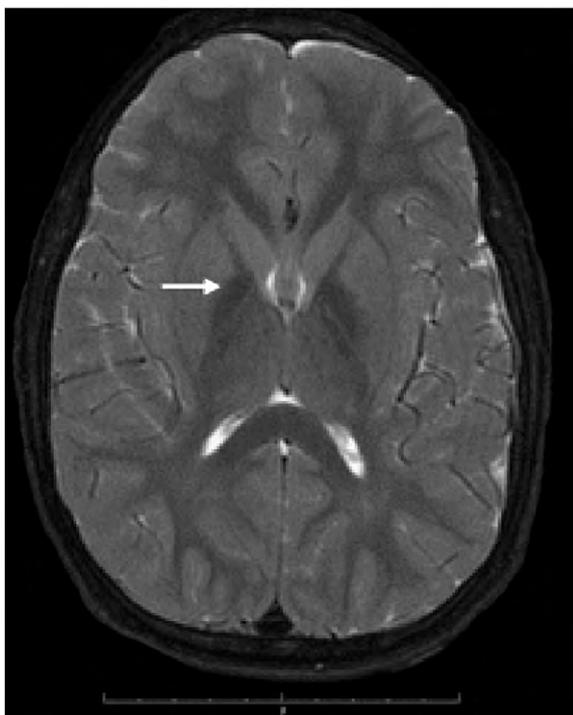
T2-weighted MRI of a 9-year-old patient with phospholipase A2G6-associated neurodegeneration (PLAN). There is symmetrical signal attenuation in the globus pallidus compatible with excessive iron deposition (arrow). From [66], with permission.
